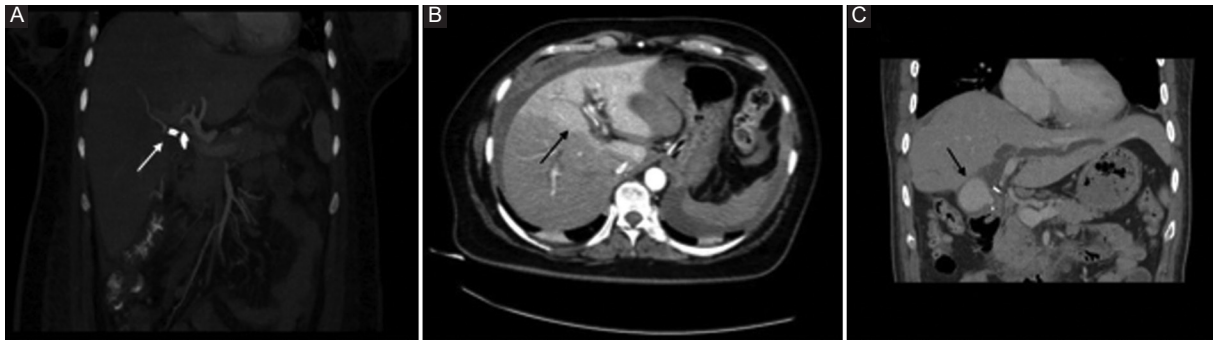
A: coronary computed tomography angiography showing a right hepatic artery injury due to clip placement following laparoscopic cholecystectomy. B: coronary computed tomography angiography showing a significant perfusion abnormality in the right hepatic lobe following a right hepatic artery injury. C: coronary computed tomography angiography showing a right hepatic artery pseudoaneurysm following this injury.
